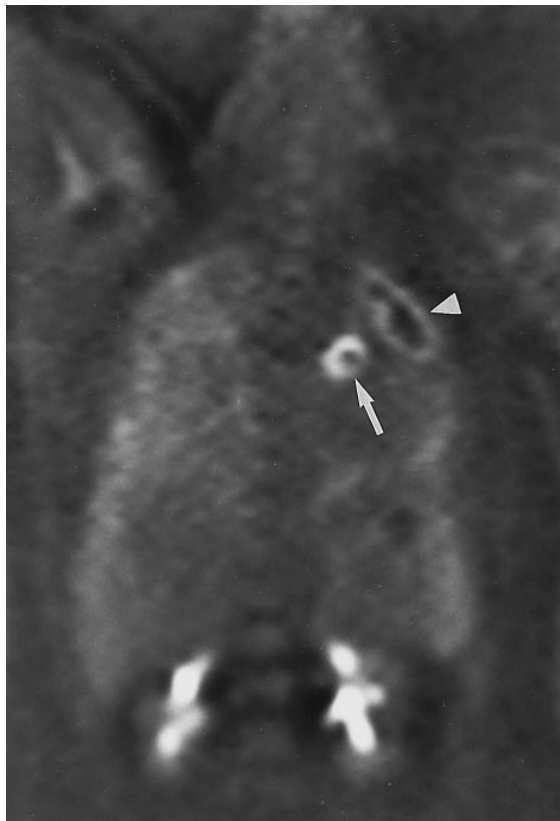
Coronal FDG-PET depicts two regions of increased metabolism: one in the left hilar region corresponding to the primary choriocarcinoma of the left pulmonary artery (arrow); the other region in the left upper lobe with slightly increased metabolism in its periphery representing an abscess formation (arrowhead).
